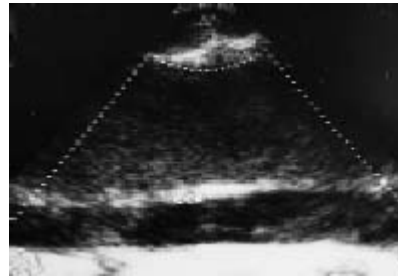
Longitudinal ultrasound scan of right side of the neck shows a linear cystic lesion with internal echoes lying anterior to the common carotid artery (CCA).
